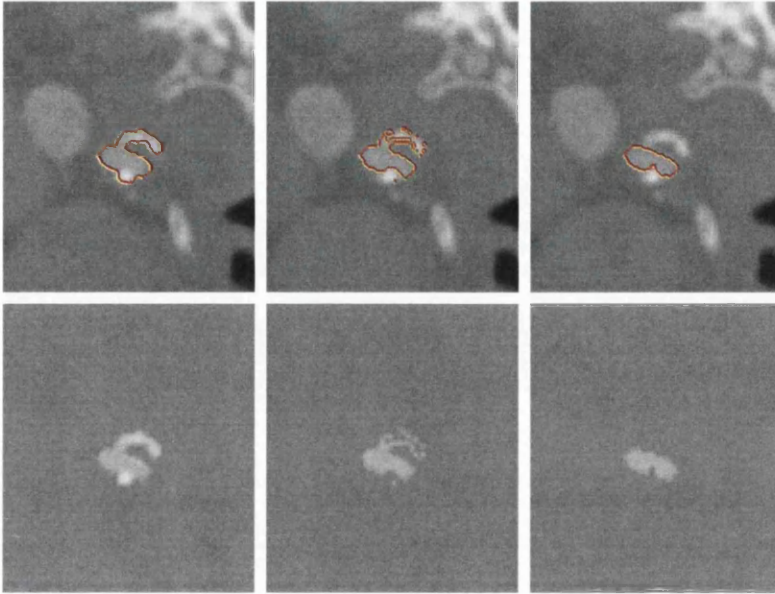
Image slice from CT image dataset 4 showing contours (top row) and corresponding pixels (bottom row) extracted using: from left to right - GPF deformable model, GPF deformable model with intensity threshold and GPF deformable model with region constraint.
